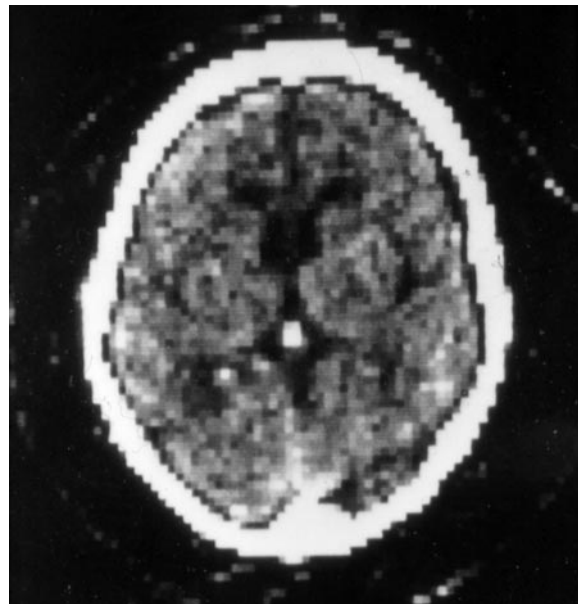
CT image of the head obtained with an early CT scanner. The scan plane resolution is on the order of 3 mm for a field of view of 25 cm with an 80×80 matrix and a z-axis resolution of approximately 13 mm.
